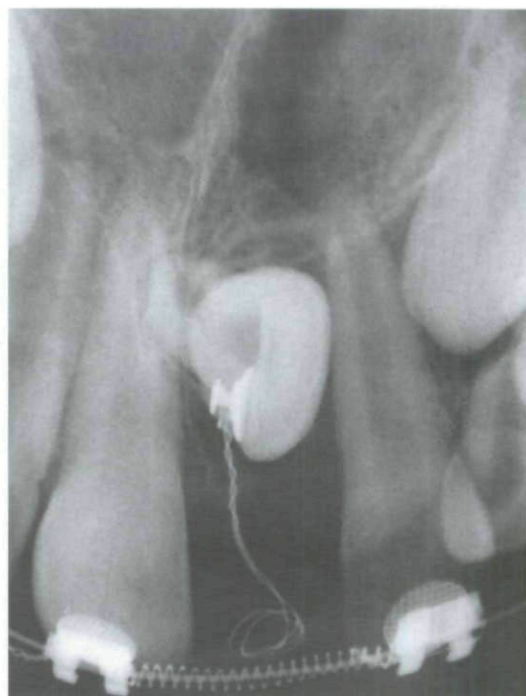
Periapical radiograph showing the button and the ligature wire bonded to impacted tooth.
